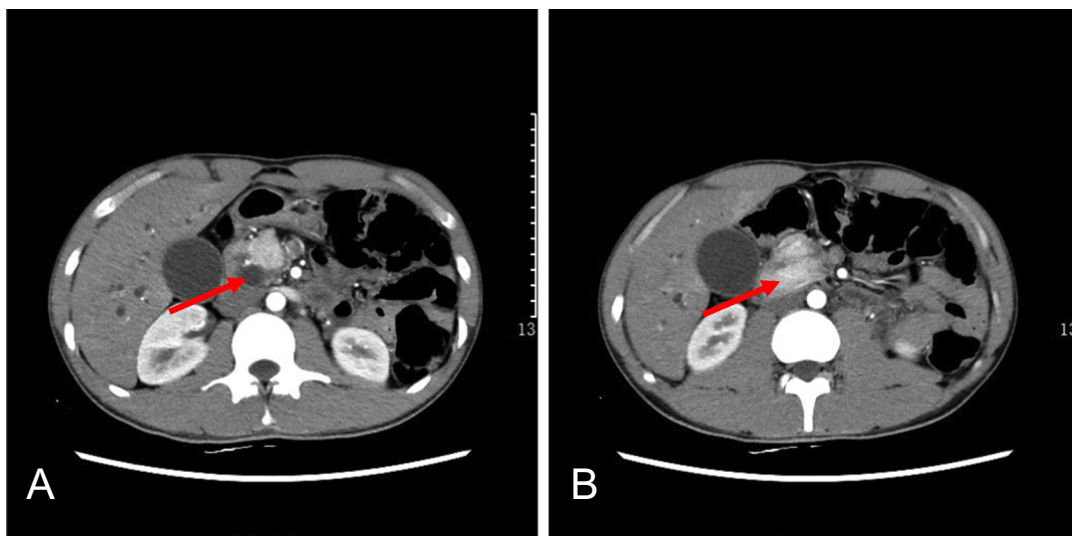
Axial Computed Tomography showing A: dilated common bile duct. B: Enlarged pancreatic head with no signs of neoplasm.
